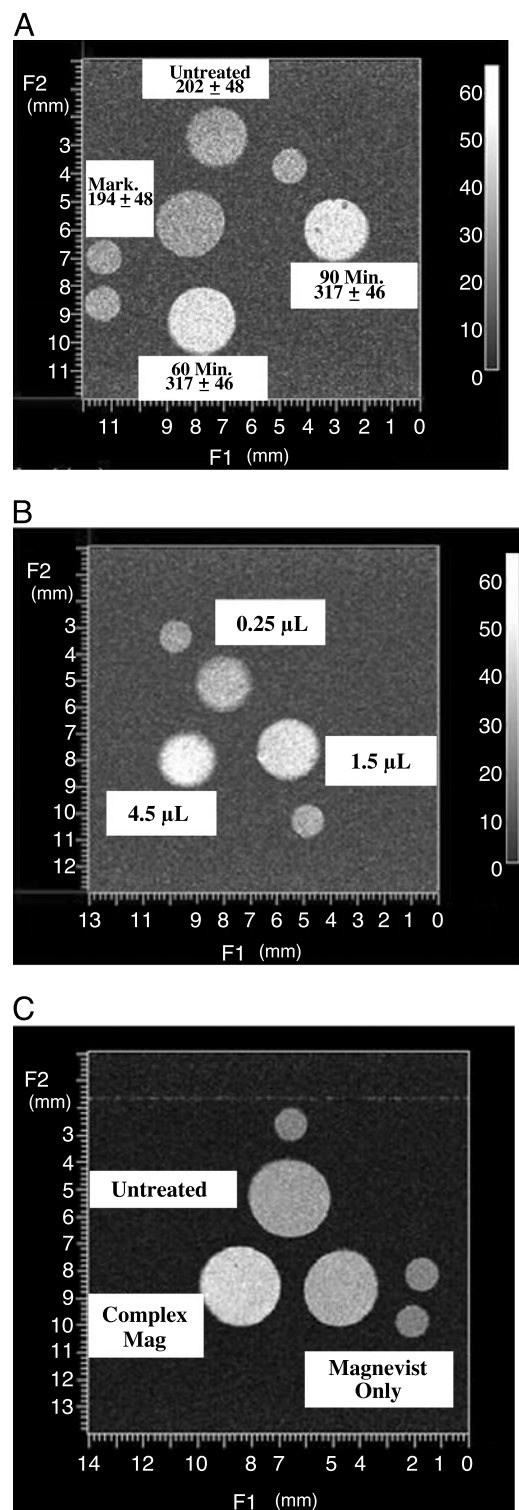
In vitro* MRI of K564 cells after transfection with the TjRscFv-Lip-Mag nanocomplex. After transfection with either free Magnevist[®] or the noncomplex encapsulating Magnevist[®] the cells were pelleted and washed with serum-free medium, and MRI performed using a 4.7T Varian NMR. The imaging protocol consisted of T1-weighted spin-echo imaging sequences (TR/TE, 1000/13 msec) to verify the image enhancement and a saturation-recovery MR sequence with variable echo times for the T1 measurement. (A) Time-dependent transfection. The values given are relative intensities. (B) Variation in relative intensity with the amount of Magnevist[®] included in the complex (in microliters). (C) Comparison of relative intensity of the TjRscFv-Lip-Mag complex versus free Magnevist[®]. The small circles in all images are markers for sample orientation.
